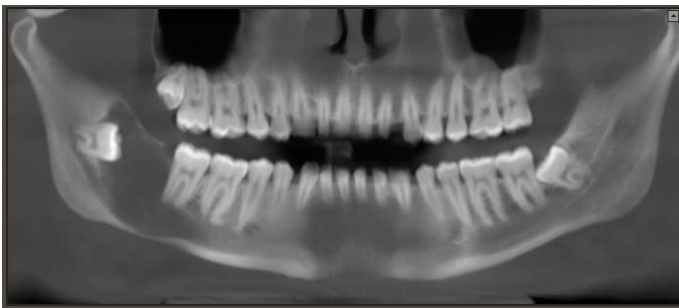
Preoperative Orthopantomograph showing extent of lesion involving impacted right mandibular third molar.
